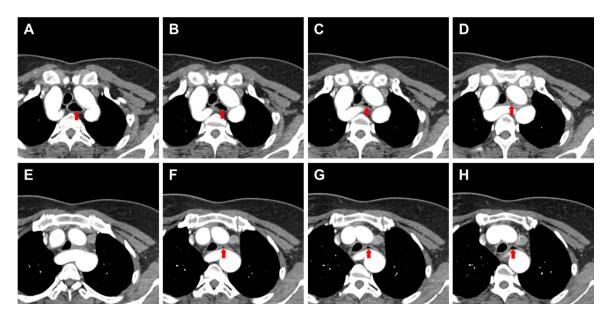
Contrast-enhanced computed tomography. Double aortic arch as a complete vascular ring encircles the trachea and esophagus. Red arrows indicate the compressed esophagus by the aortic ring.
